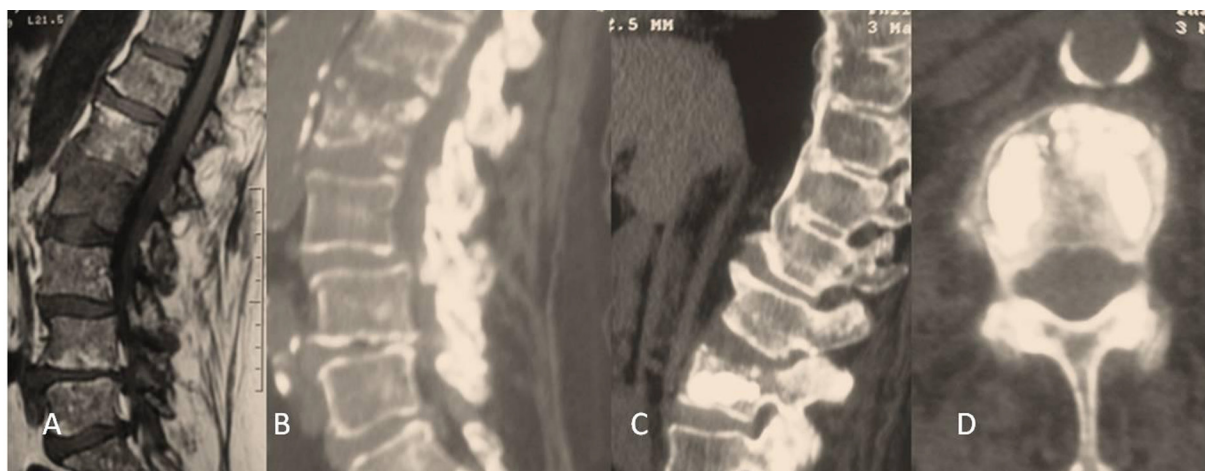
T1 weighed 227 MRI images of a case before KP procedure (a) and sagittal CT image (B) and same case's postoperative sagittal (c) and axial (d) CT images.
